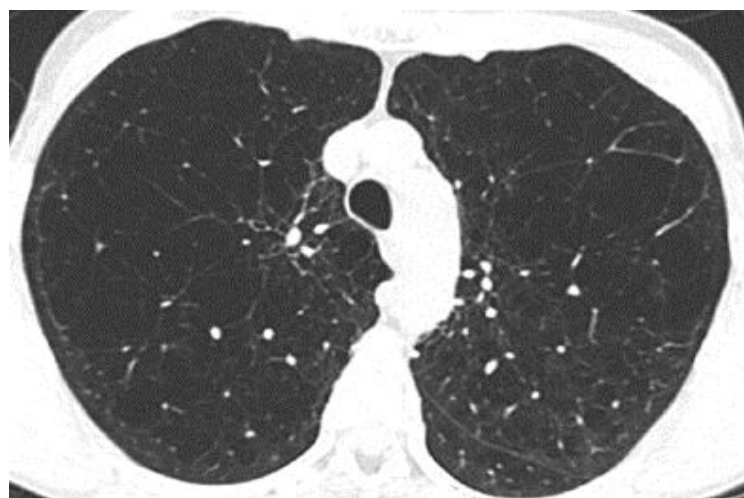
HRCT picture in a upper lobe emphysema
